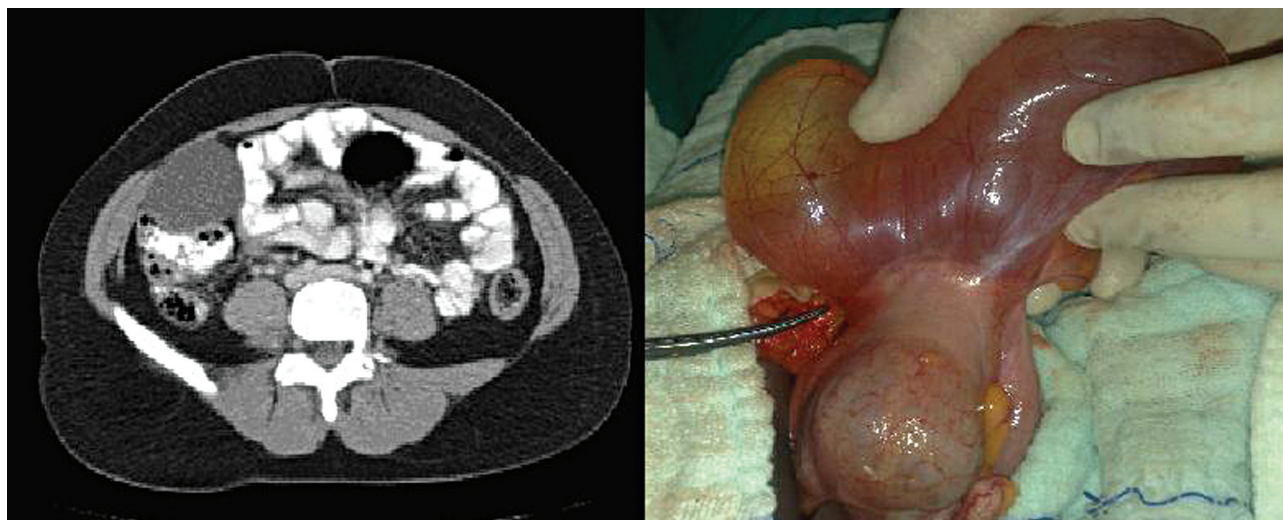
The contrast-enhanced abdominal CT findings of the cystic mass and intraoperative view of the duplication cyst perforation as indicated by the scissor tip.
